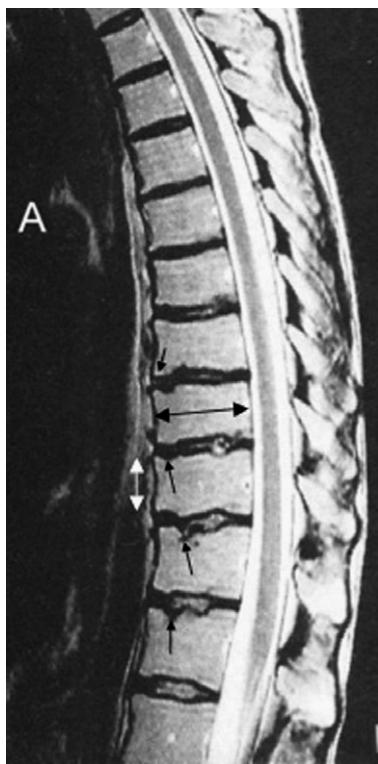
An example of Scheuermann's disease of the thoracic spine. Sagittal T2-weighted MR image showing (i) irregularity of three contiguous vertebral body end-plates anteriorly (short black arrows), (ii) some loss in vertebral body height anteriorly (white arrows), and (iii) an increase in the anteroposterior diameter (long black arrow) of three contiguous vertebrae. With permission from: McCall IW. Radiology of the thoracic spine. In: Giles L G F, Singer K P (eds) Clinical anatomy and management of thoracic spine pain. Oxford, Butterworth-Heinemann (2000) p 188.
